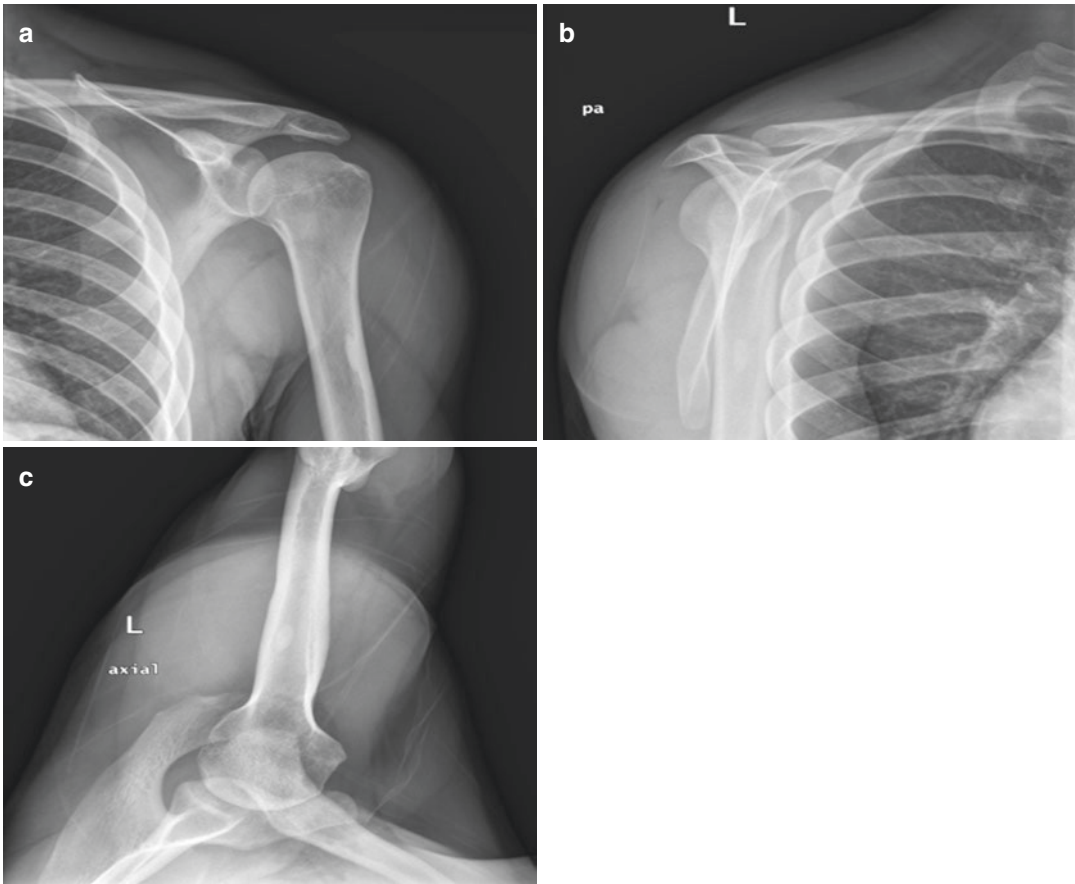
Unremarkable, plain radiographs of the left shoulder. (a) Anterior-posterior. (b) Scapular Y. (c) Axillary
